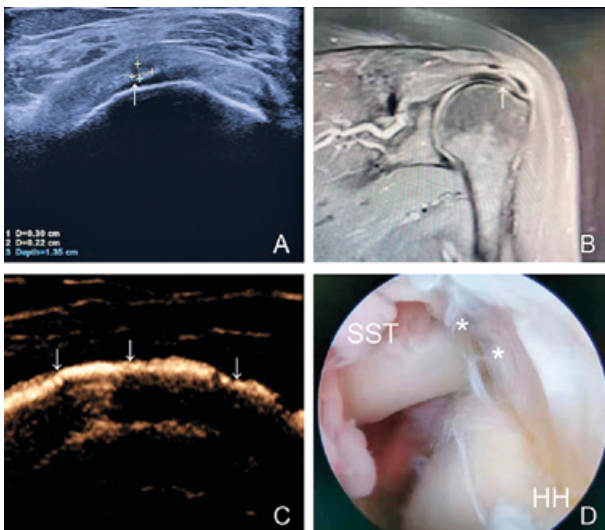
A 50-year-old female with partial-thickness tear of supraspinatus on articular side: (A) US showed that the supraspinatus tendon bursal plane was intact (↑), and the hypoechoic zone could be detected near the articular side of the supraspinatus tendon (*); (B) MRI showed high signal shadow at the articular surface of the supraspinatus tendon (↑), indicating a partial-thickness tear of the supraspinatus tendon on the articular side; (C) PUSB results suggested that the contrast agent was evenly distributed along the supraspinatus tendon on the bursal side after entering the subacromial bursa, and no contrast agent was found in the supraspinatus tendon; (D) Shoulder arthroscopy revealed a partial-thickness tear of the supraspinatus tendon on articular side (). SST = supraspinatus tendon; HH = humeral head.
